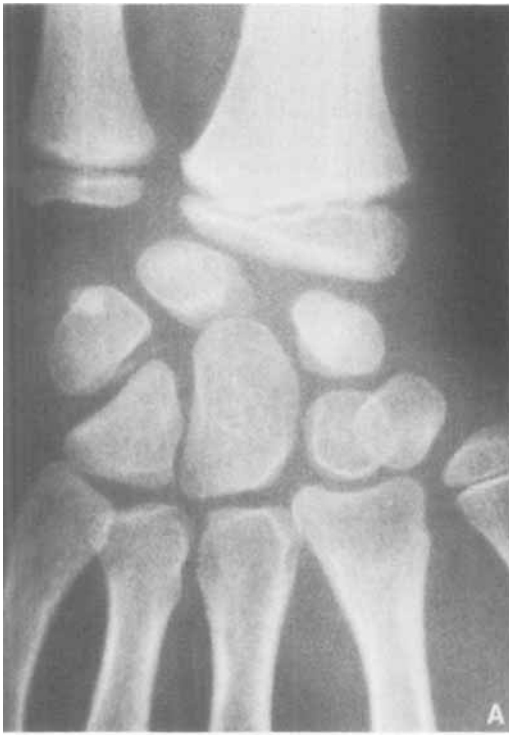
A and B. Anteroposterior and lateral roentgenograms 7 weeks after injury.
